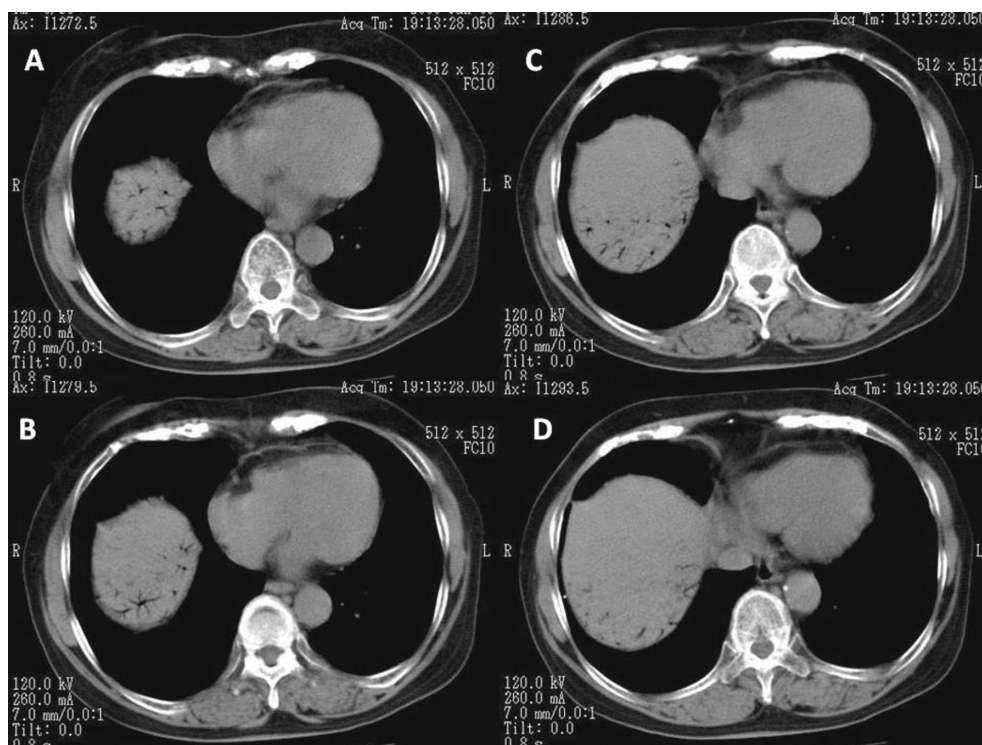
Four serial pictures obtained by Computed Tomography demonstrated multiple linear gas densities in peripheral branches of the portal vein within the liver.
